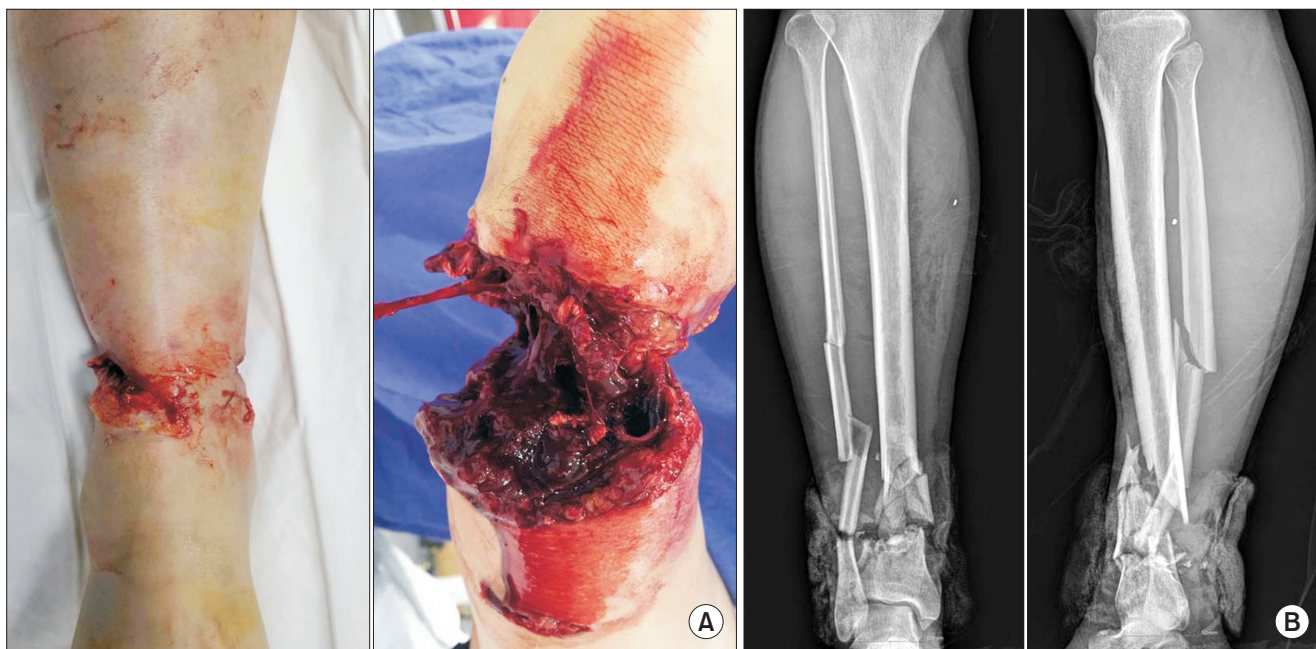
Photographs (A) and radiographs (B) showing amputation with comminuted fracture of the tibia and fibular at above ankle joint.
